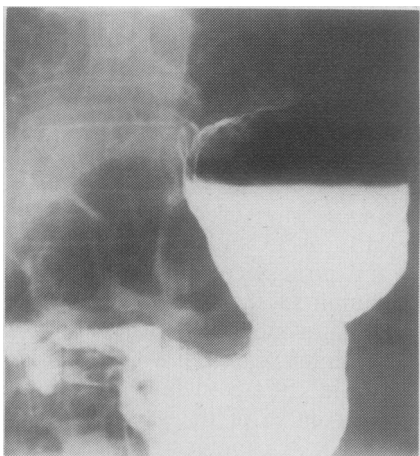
Barium-meal x-ray film, showing large irregular, polypoid filling in gastric antrum.
